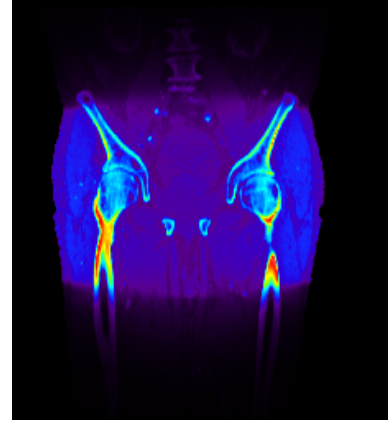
Isocentric slices for Pat. D for a cone beam CT acquisition (360° tube rotation). The slice positions are marked in the CT-slices shown in (n) - (p).
